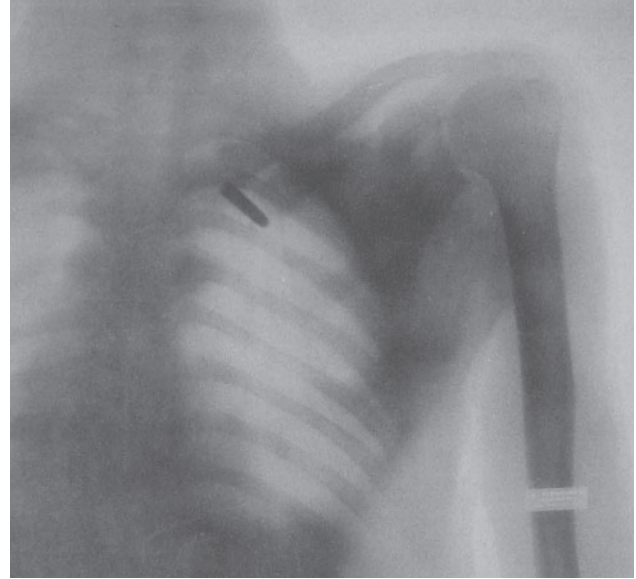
Captain William C. Borden, MD, wrote in his 1900 history of the use of roentgenography in the Spanish-American War, "[This soldier was] wounded at Malate, Philippine Islands, July 31, 1898. He was transferred to the division hospital, Presidio, San Francisco, Cal., October 22, 1898." This radiograph, viewed from the patient's back, shows a Mauser bullet, which had passed through the spine, lying 2 in. to the right of the spine over the third intercostal space. The chest film "demonstrated that the [patient's] symptoms were due to the original traumatism and not to the presence of the bullet."
